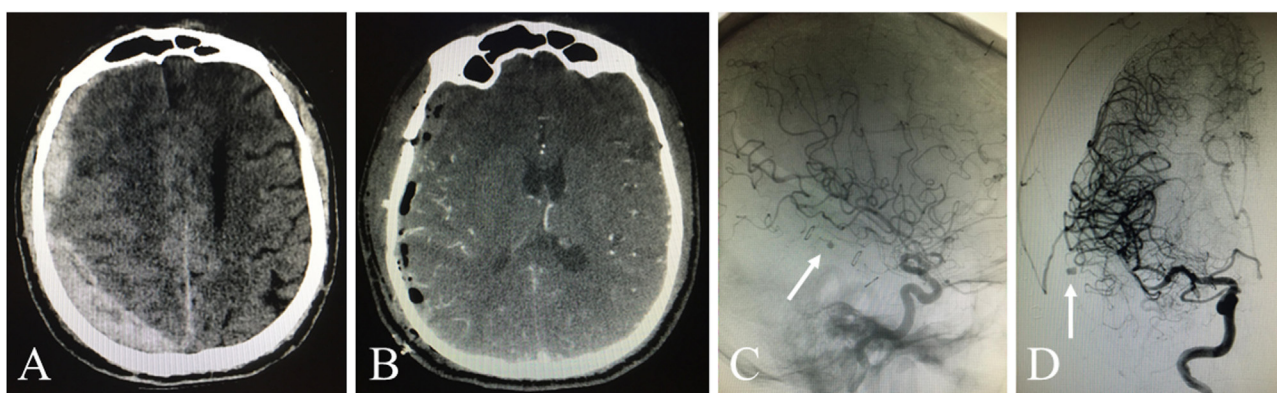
Patient 2. Image A: preop noncontrast CT. Image B: postop CT with contrast. Images C and D: lateral and AP arteriography projections of right internal carotid artery, the white arrows point the M4 aneurysm; its cortical location may facilitate the aSDH formation.
